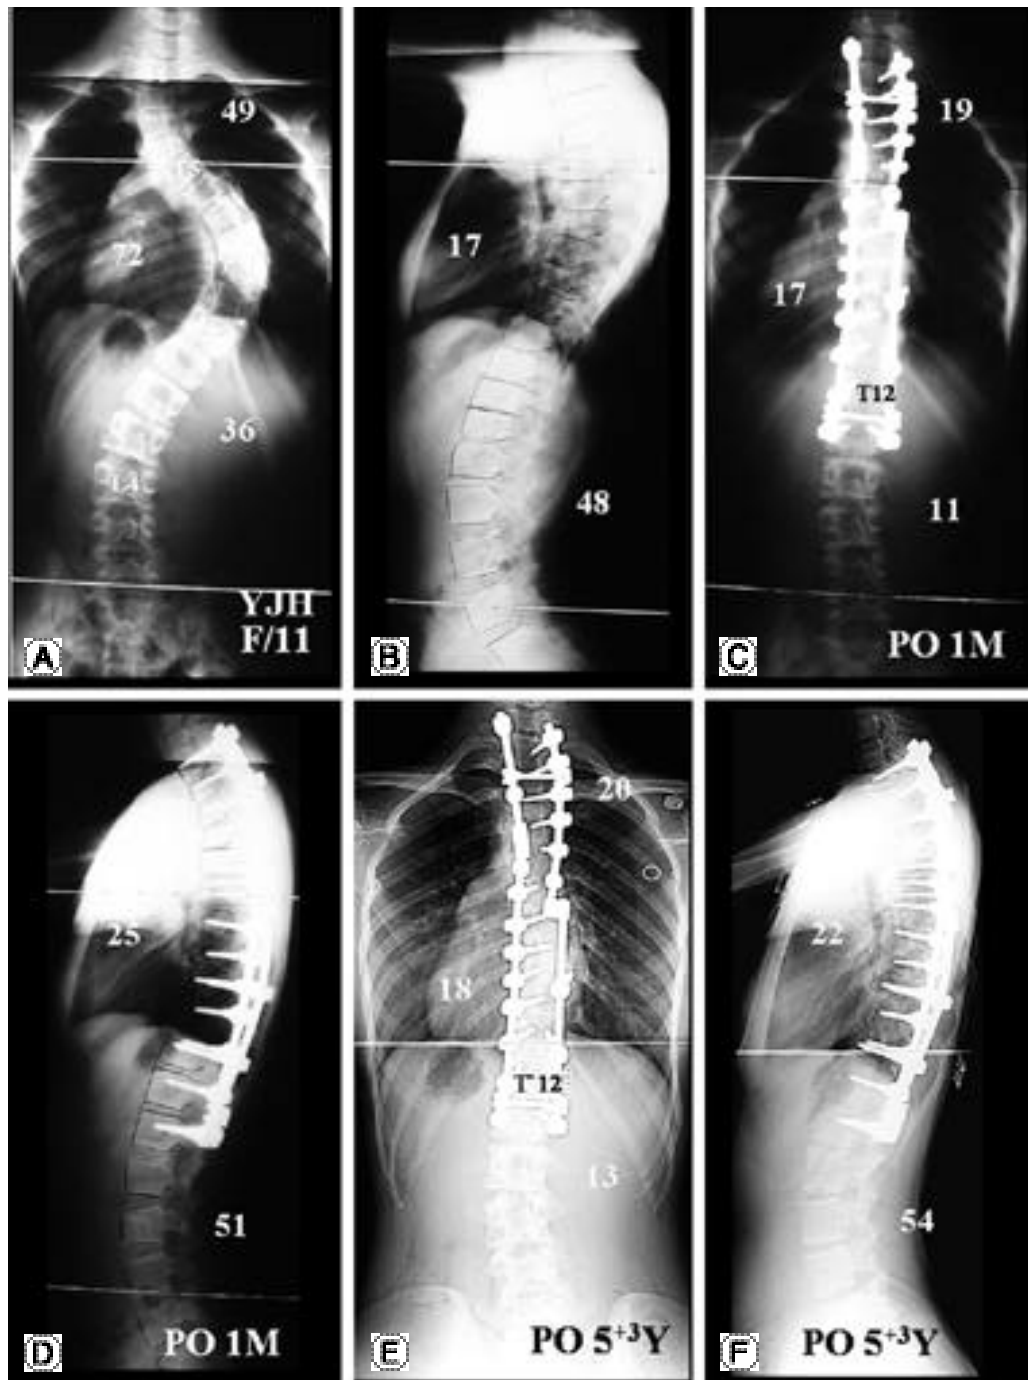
A 11-year-old girl with double thoracic curve. (A) Preoperative anteroposterior radiograph shows 72 ° main thoracic curve and 49 ° proximal thoracic curve. (B) Preoperative lateral radiograph. (C) Anteroposterior radiograph taken 1 month after surgery. The main thoracic curve was corrected to 17 °, and the proximal thoracic curve was corrected to 19 °. (D) Lateral radiograph taken 1 month after surgery. Thoracic kyphosis was improved also. (E, F) Anteroposterior and lateral radiographs taken 5 years and 3 months after surgery. Coronal and sagittal alignments were well maintained during the follow-up.
